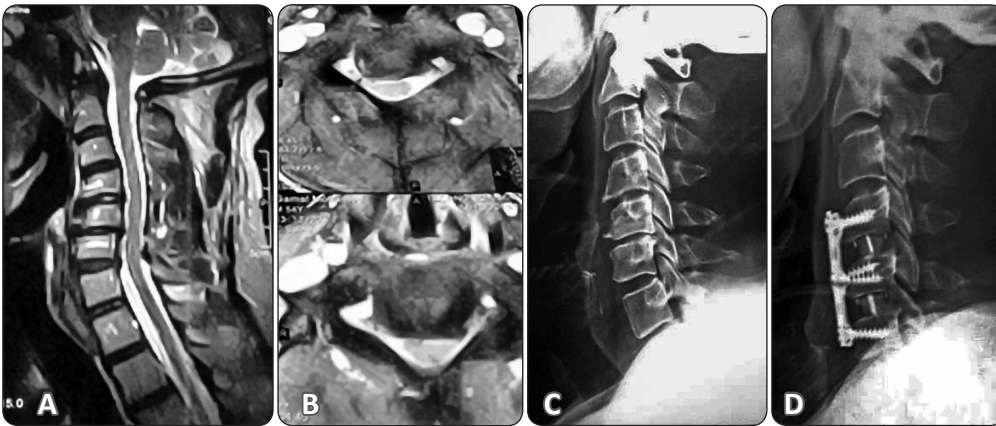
A and b: preoperative MRI cervical spine showing CDP C4-5 and C5-6. C: preoperative X-ray cervical spine showing narrowing of disc spaces. d: ACDFP was done and follow up X-ray cervical spine after 3 months showing bone fusion restoration of disc height.
